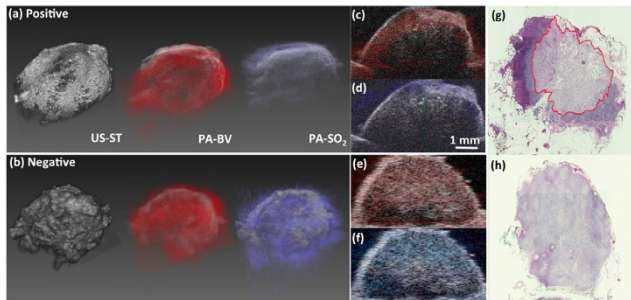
(a) and (b) show the volumetric reconstruction of the ultrasound (US) and superimposed photoacoustic (PA) data acquired on colorectal nodes that tested positive (g) and negative (h) for colorectal cancer, respectively. The structural (ST: gray), blood volume (BV: red), and oxygen saturation (SO₂: blue) metrics used for node classification is also shown in representative cross-sectional slices (c through f).
